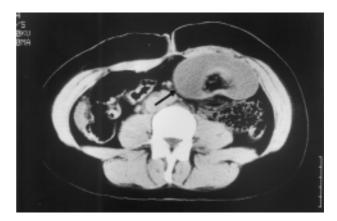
Abdominal computed tomography. Sausage-shaped lesion (arrow), containing a soft tissue mass with the density of fat.
